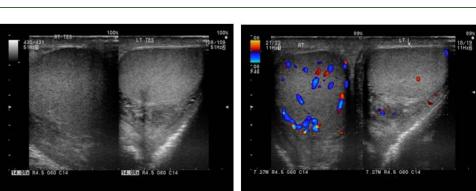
(a and b): Gray scale and colour sonogram shows heterogeneous right testis with markedly increased vascularity on doppler study.findings consistent with right sided orchitis.
